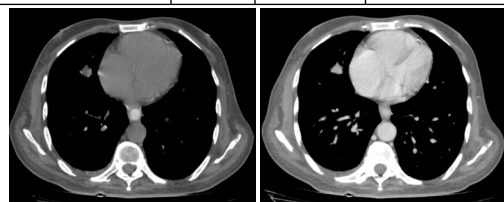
Computed Tomography of a 62-Year-Old Man Presenting With Chest Pain and Cough. Plain CT scan shows a round mass in the right lung. Enhanced CT scan shows moderate homogeneous enhancement in the mass which was verified to be lung cancer.
